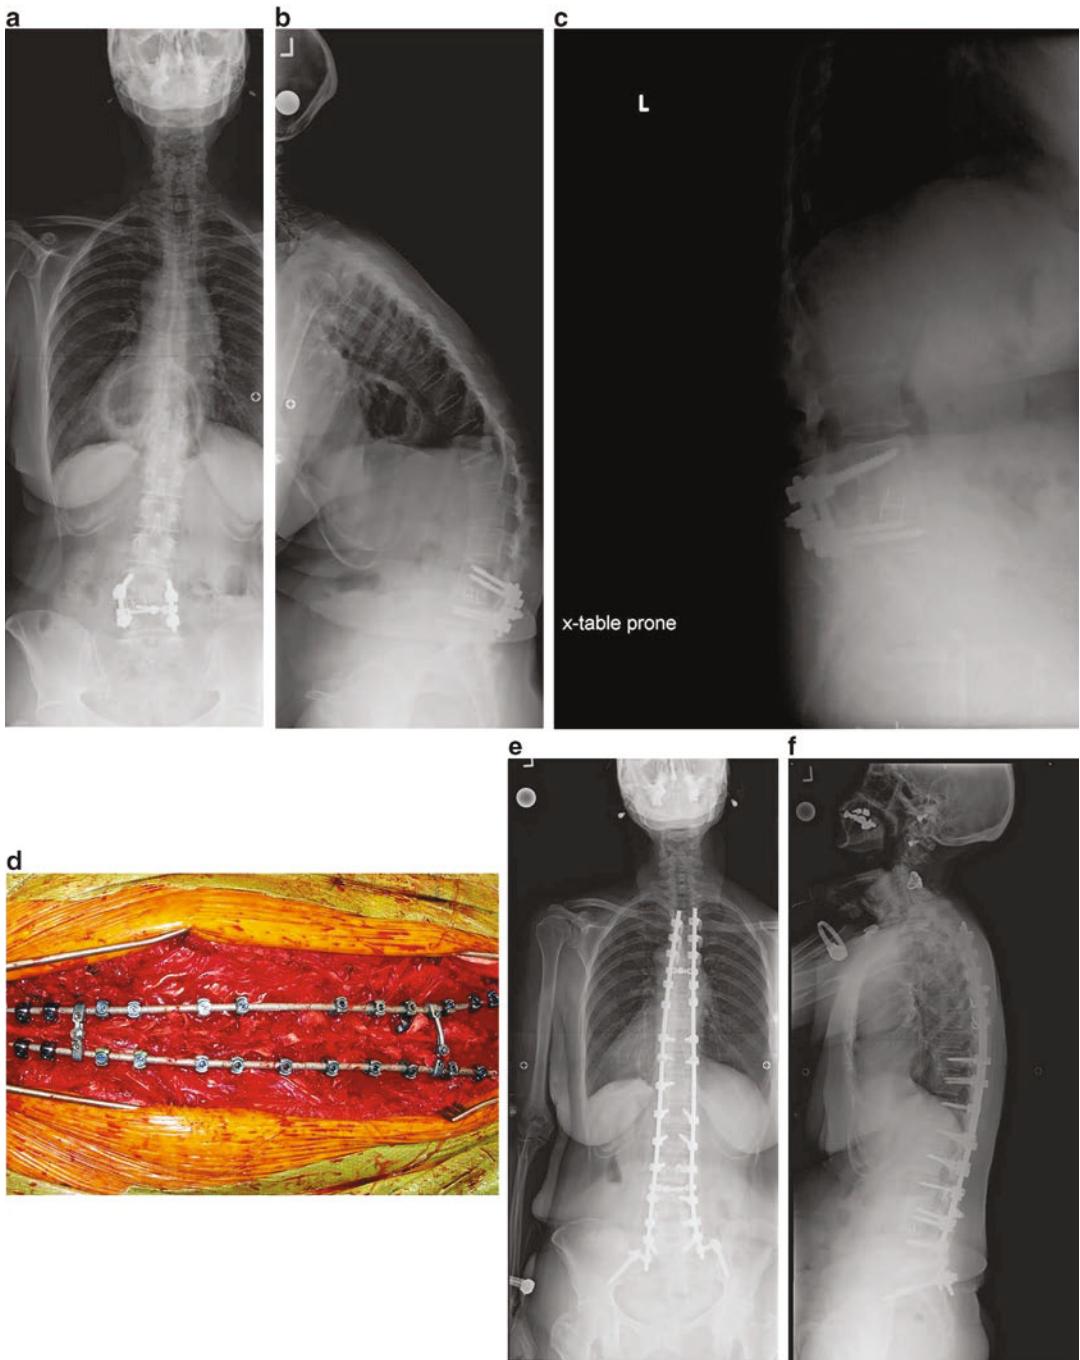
Case example of Ponte osteotomies. (a) Standing AP 36-inch scoliosis x-ray of patient with prior L4–L5 TLIF. (b) Standing lateral 36-inch scoliosis x-ray demonstrates severe sagittal imbalance and rounded kyphosis. Disc spaces above L4–L5 fusion are still open. (c) Prone hyperextension lateral x-ray demonstrates significant correction and relatively mobile discs. (d) Instrumentation placed with multiple Ponte osteotomies through thoracolumbar junction and upper lumbar spine. (e) Standing postoperative AP 36-inch scoliosis x-ray demonstrates T4–iliac instrumented fusion. (f) Standing postoperative lateral 36-inch scoliosis x-ray demonstrates restoration of normal spinal alignment
